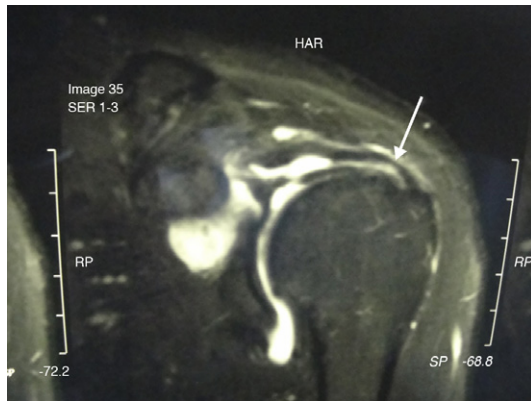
T2-weighted MRI study of the left shoulder performed three months after levofloxacin exposure shows a supraspinatus tendon tear (arrow), corresponding to a 40%–50% thinning, near its insertion on the greater tuberosity of the humerus.
